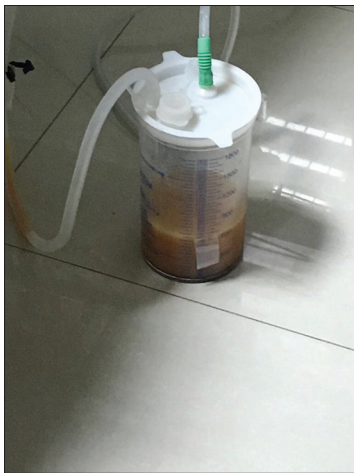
X-ray shows milky white color fluid in drainage bottle
